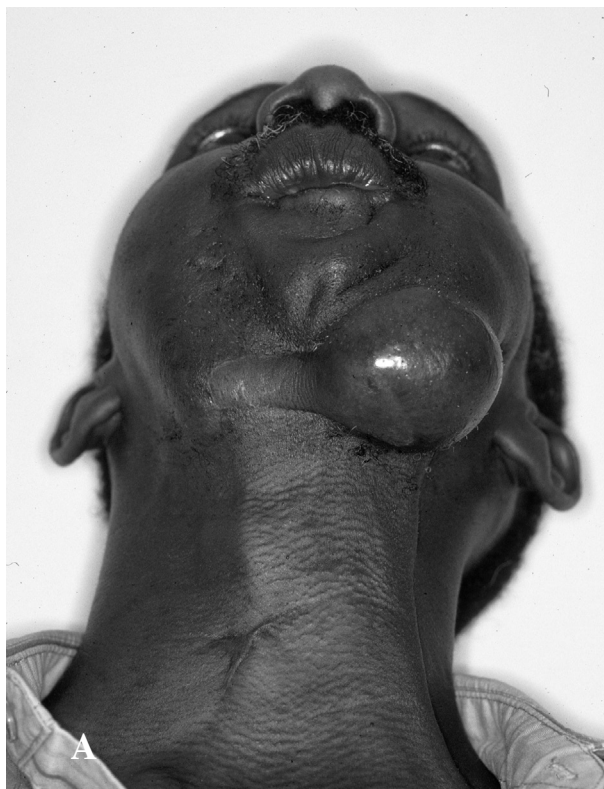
A. The clinical appearance, and B. MRI of a patient who underwent several enucleation and curettage surgeries for ameloblastoma of the mandible. At this time, he displays soft tissue persistence of his tumor in the facial skin. In addition, substantial floor of mouth and pharyngeal extension of the tumor was noted. The patient subsequently underwent wide excision of this persistent tumor, with the administration of postoperative radiation therapy.
